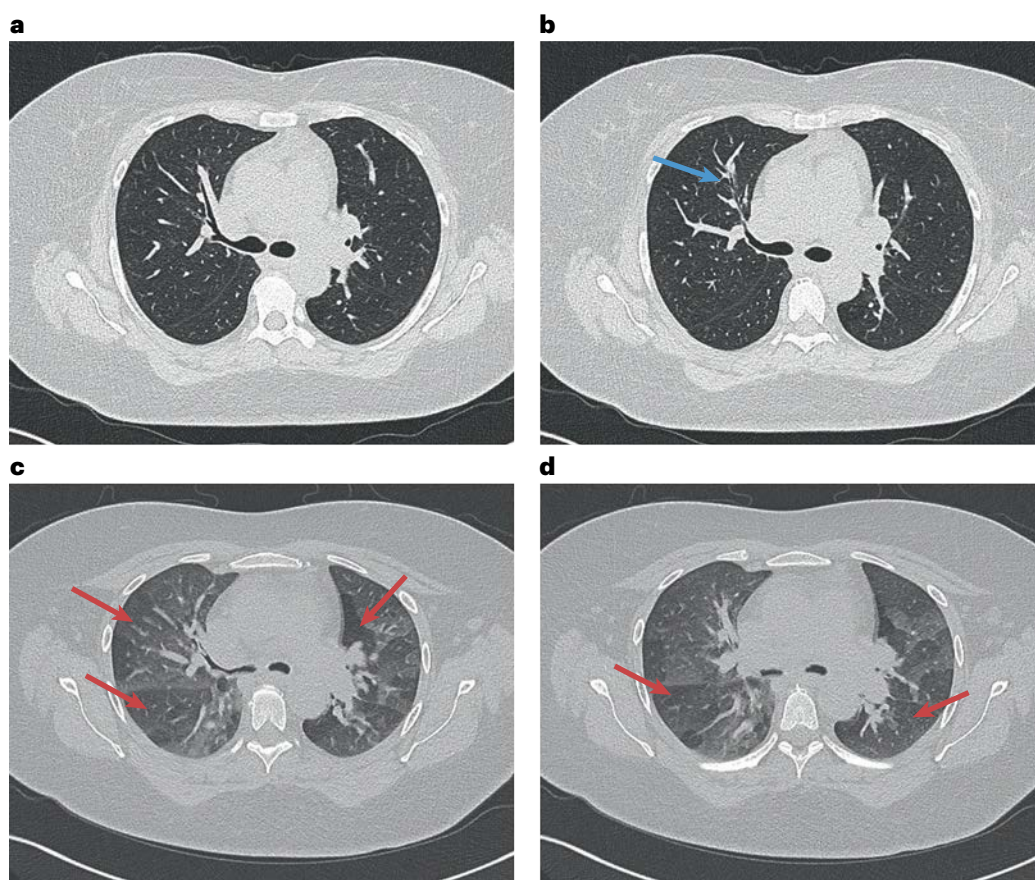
High-resolution chest CT of obstructive bronchiolitis. a, b, Inspiratory high-resolution CT (HRCT) images of obstructive bronchiolitis in a 72-year-old man with rheumatoid arthritis (RA) show discrete bronchiectasis (blue arrow). c, d, Expiratory HRCT images of the same patient show air trapping (red arrows).
